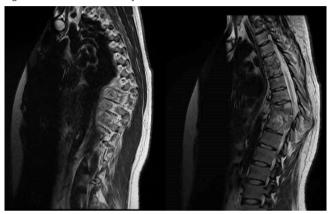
Thoraco-lumbar MRI - Severe kyphotic deformation, epidural abscess and spinal cord compression on the T8-T10 levels.
